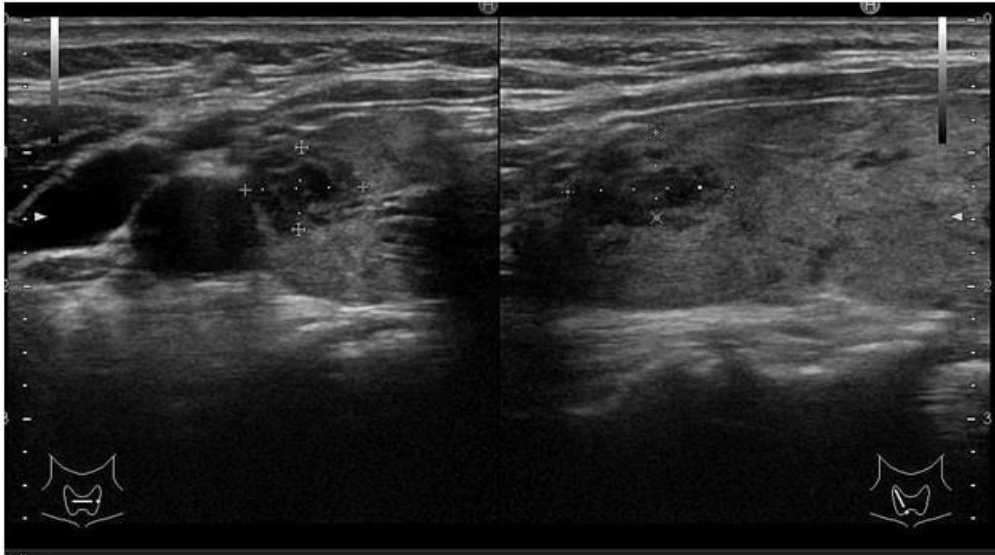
Thyroid ultrasonography image showing an 8-mm hypoechoic tumor in the right lobe of the thyroid.
